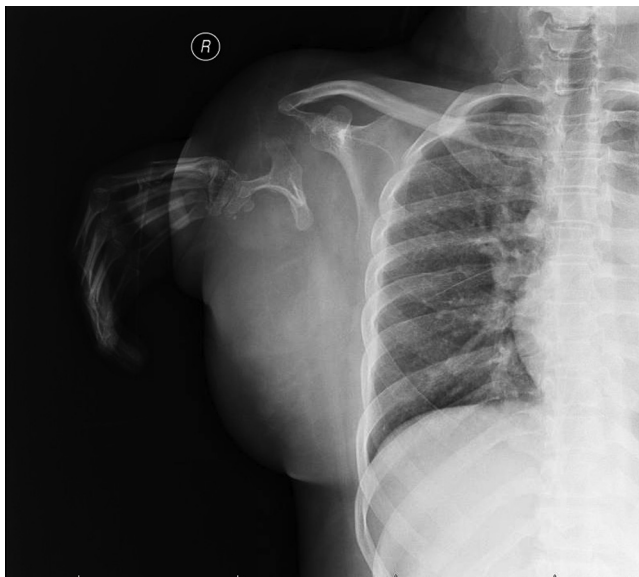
Anteroposterior radiograph of the right shoulder revealing a markedly dysmorphic and foreshortened upper limb, classically associated with thalidomide exposure in utero.
